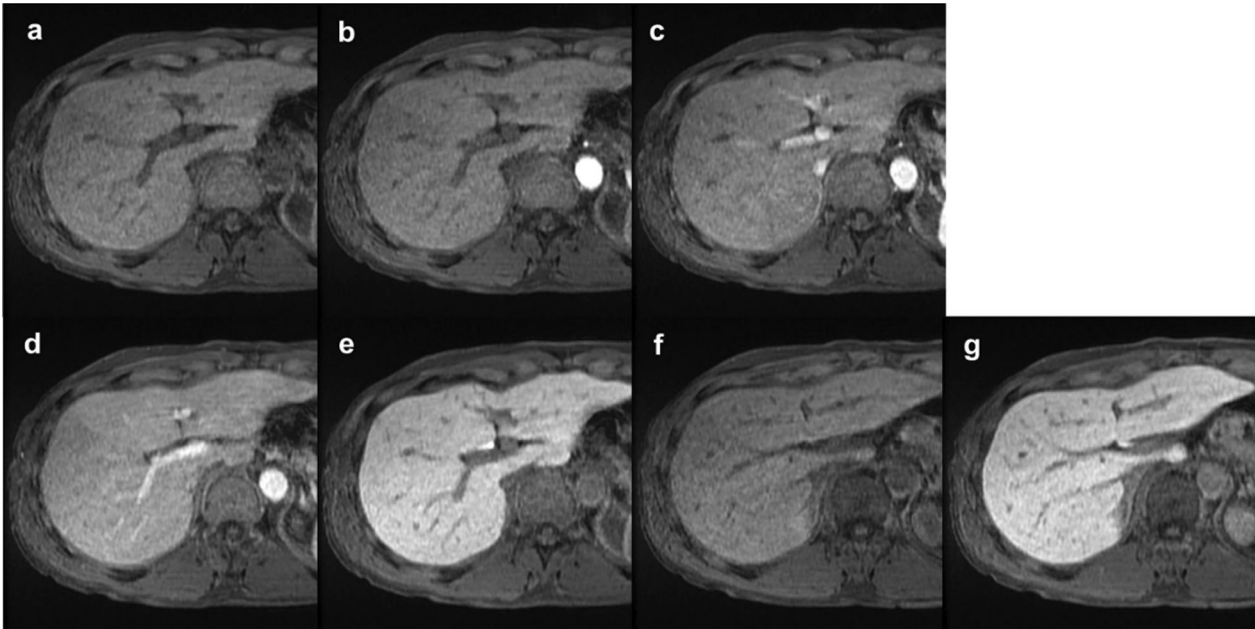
Representative images of a 60-year-old male with citrullinemia. Magnetic resonance (MR) images acquired with the 10-s scan protocol (a, pre-contrast; b, first arterial phase; c, second arterial phase; d, portal venous phase; e, hepatobiliary phase) are shown. Images a–e were acquired at the level of the posterior segmental branch of the portal vein. Images f and g show the level of the inferior right hepatic vein (IRHV). The MR images acquired with the 10-s scan protocol demonstrate the highest visual score for overall image quality (an average visual score of 3.5). The average visual score for each item is as follows: the outline of the liver (pre-contrast, 3; first arterial phase, 2.5; second arterial phase, 2.5; portal venous phase, and 3; and hepatobiliary phase, 4); IRHV (pre-contrast, 1.5 and hepatobiliary phase, 2.5); portal vein, 2.5; and hepatic artery (first arterial phase, 1 and second arterial phase, 2). The optimal arterial phase was obtained in the second arterial phase
